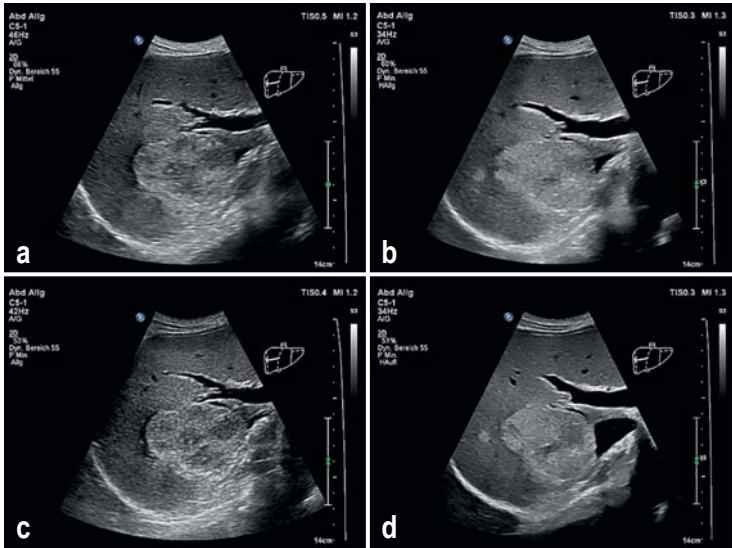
a) Conventional B scan sonography of a solid echogenic space occupying lesion of the liver; b) tissue harmonic imaging enables a better outline of the lesion through modification of the soft tissue exposure compared with the conventional B scan. c) Spatial compounding enables the sound waves to spread simultaneously into different directions and leads to an improved signal to noise ratio, thus reducing artefacts. d) Optimized exposure of the liver focus with simultaneous combination of tissue harmonic imaging, spatial compounding, and speckle reduction technique.
